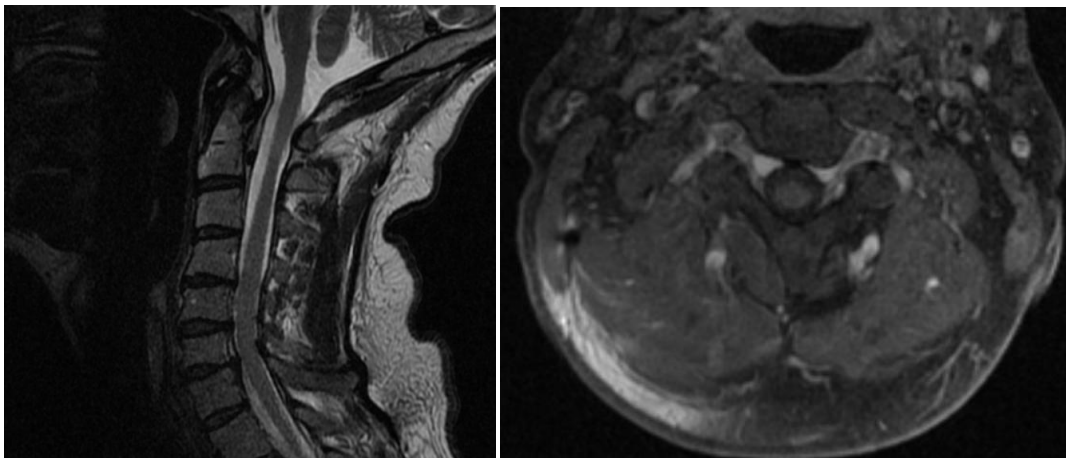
MRI of the cervical spine, 10 weeks post operative. On the left, a T2 sagittal MRI of the C-spine reveals interval regression of the cervical venous engorgement. On the right, a T1 axial image with contrast shows the significant decrease in size of the anterior cervical veins and improvement of the cervical stenosis.*
